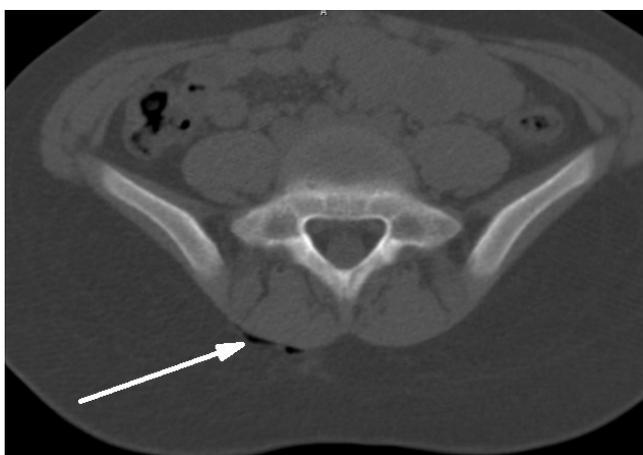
The pelvic CT scan revealed air densities in the region of the skin lesion.
